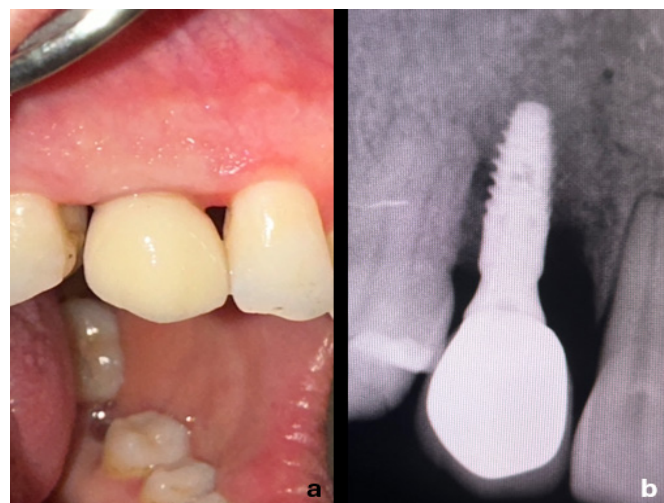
3-month post-procedure: a. mesial and distal papilla regions, b. radiographic view
